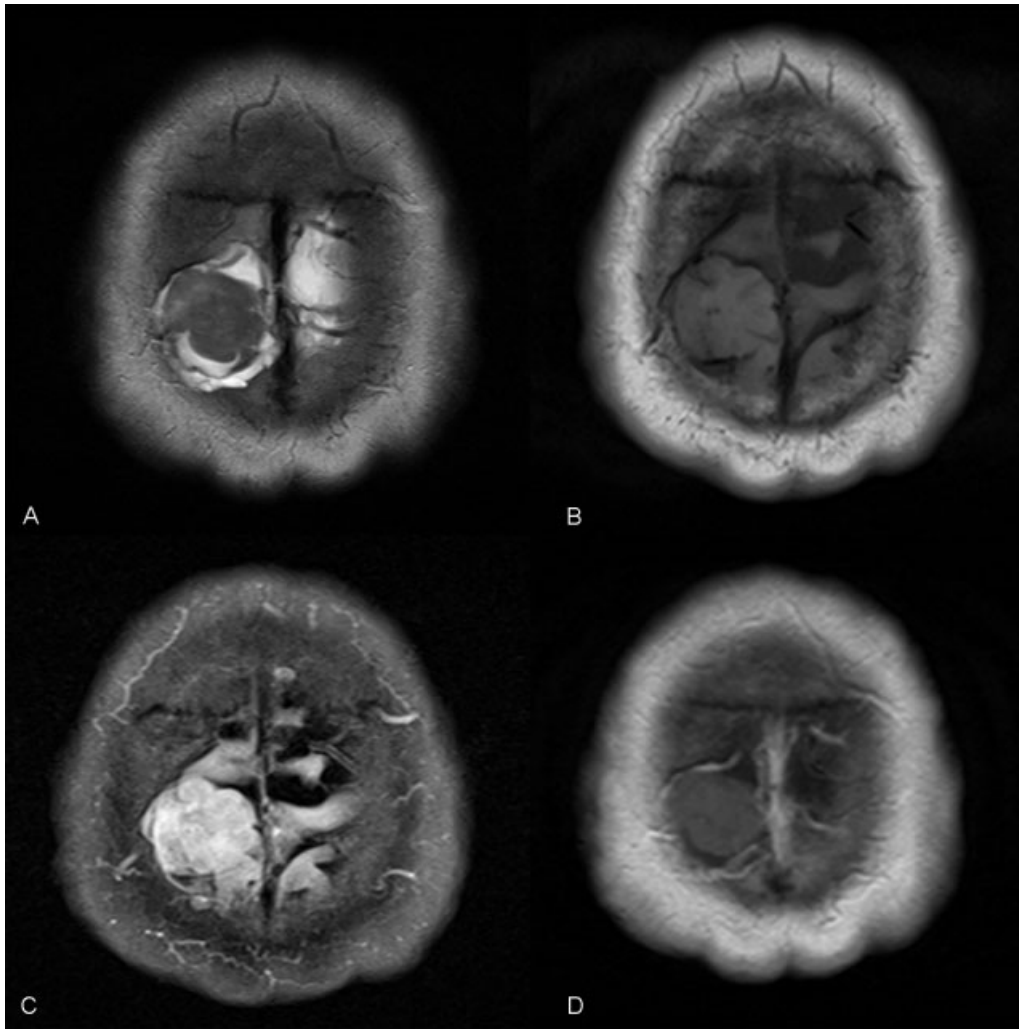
(A) Axial 5 mm SE T2 images, (B) axial 5 mm blood suppressed SE T1 images, (C) axial 5 mm FLAIR images, and (D) axial 5 mm postcontrast SE T1 images (12 mm Gadavist). CT, computed tomography; MRI, magnetic resonance imaging; SE, spin echo.
